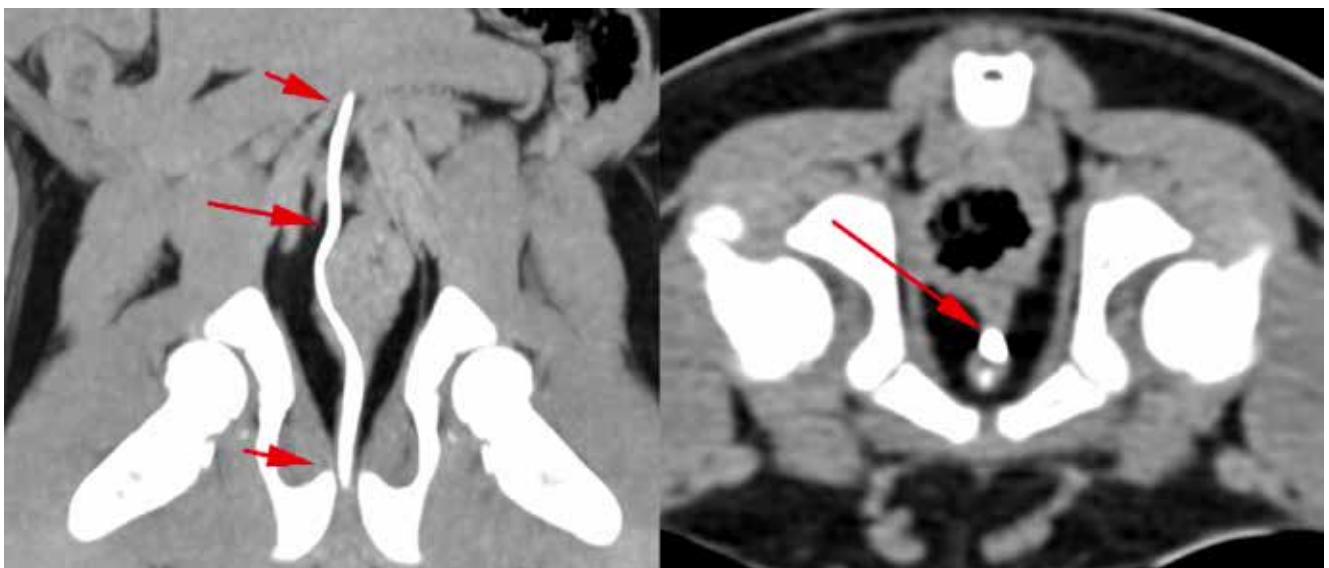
Right intramural ectopic ureter noted on CT.
